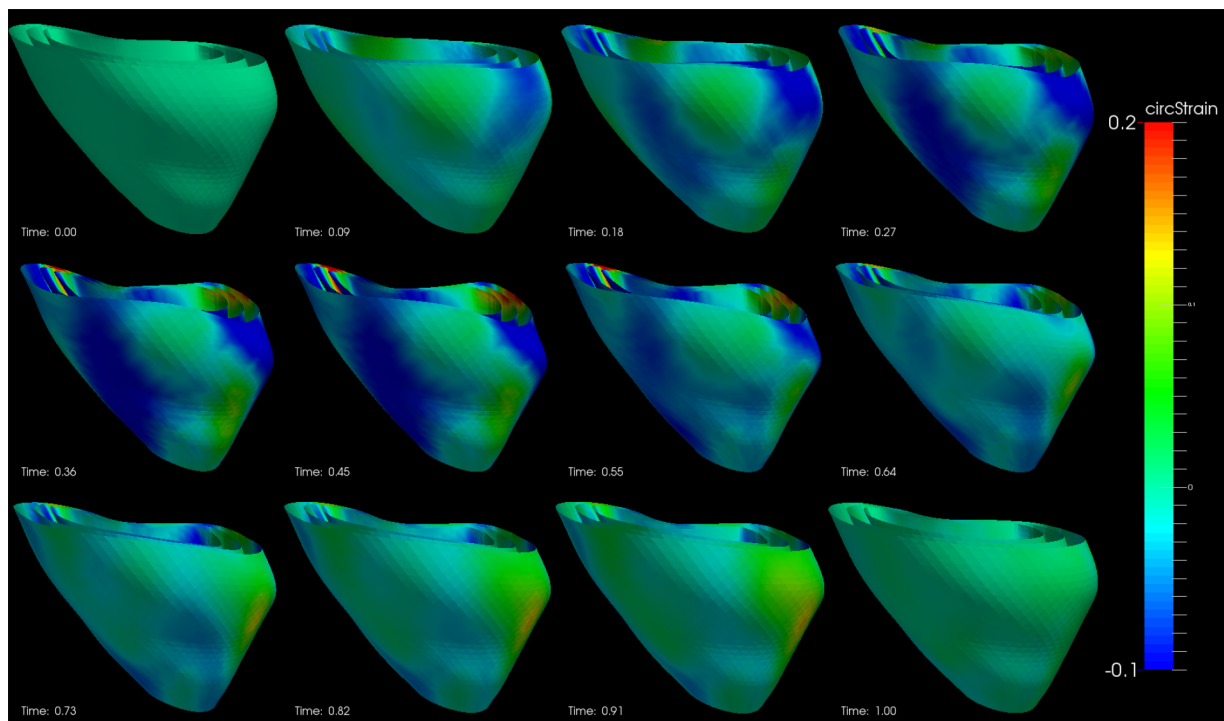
Circumferential strain of an example echocardiography sequence varying with time in a cardiac cycle. (The cardiac time is normalized between 0 and 1.)
